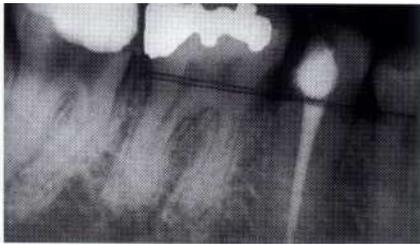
Dental radiograph of the patient shown in Figure 19-41 at the beginning of treatment.
